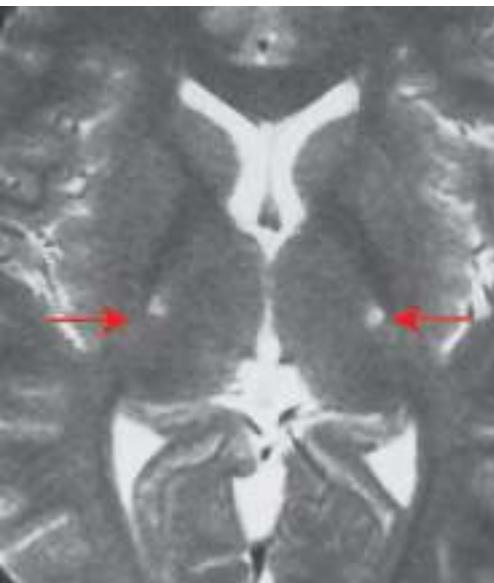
Amyotrophic lateral sclerosis. Axial T2-weighted magnetic resonance imaging (MRI) scan through the lateral ventricles of the brain reveals abnormal high signal intensity within the corticospinal tracts (arrows). This MRI feature represents an increase in water content in myelin tracts undergoing Wallerian degeneration secondary to cortical motor neuronal loss. This finding is commonly present in ALS but can also be seen in AIDS-related encephalopathy, infarction, or other disease processes that produce corticospinal neuronal loss in a symmetric fashion.
